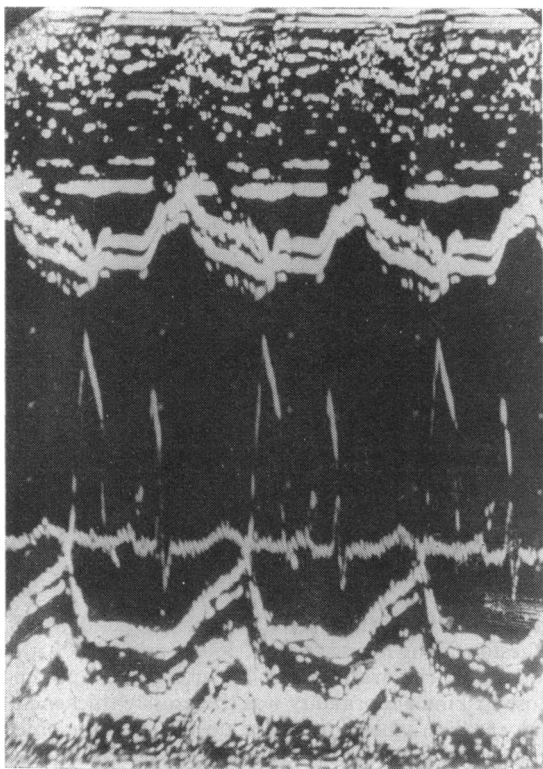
Case 6. Echocardiogram showing rapid diastolic closure rate of anterior leaflet of mitral valve, normal ventricular dimensions, and rapid outward movement of posterior ventricular wall.
